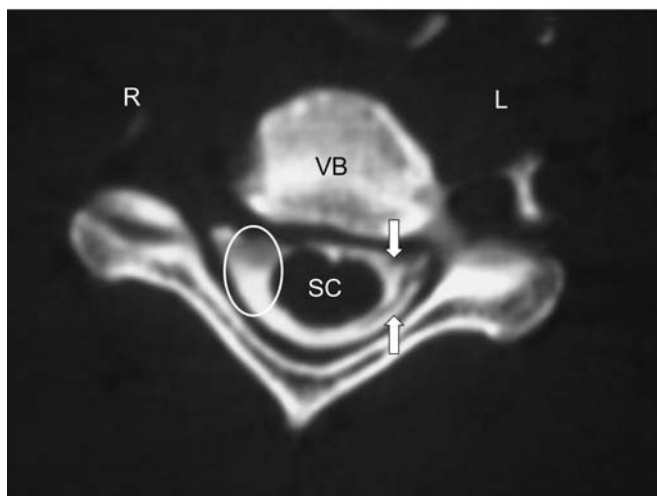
Nerve root avulsion. (a.) Axial images of CT myelogram demonstrating intact ventral (downward arrow) and dorsal (upward arrow) nerve roots at an unaffected cervical spinal level. (b.) Axial images of CT myelogram demonstrating intact ventral and dorsal nerve roots on left (arrows) and absence of nerve roots on the right (open oval). (VB=vertebral body, SC=spinal cord)
